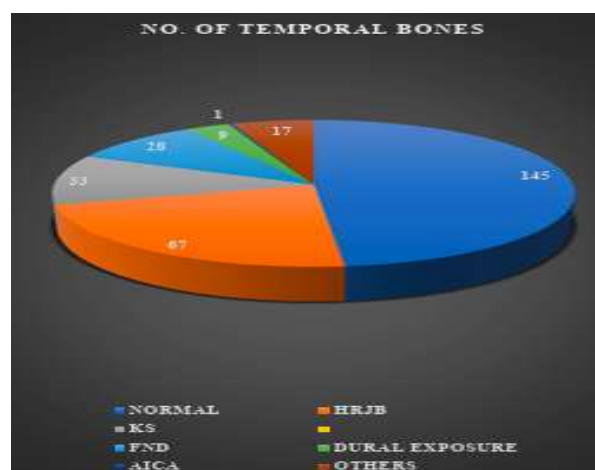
Frequency of anatomical variants detected on HRCT.
